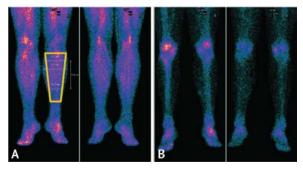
Patient K. Three-phase scintigraphy with 99 m Tc-pyrfotech (A – tissue phase, B – bone phase), diffuse decreased accumulation of a radiopharmaceutical in the soft tissues of the proximal and middle thirds of the leg in the phase of tissue blood flow; in the bone phase, no foci of hyperfixation suspicious for areas of necrosis were identified
